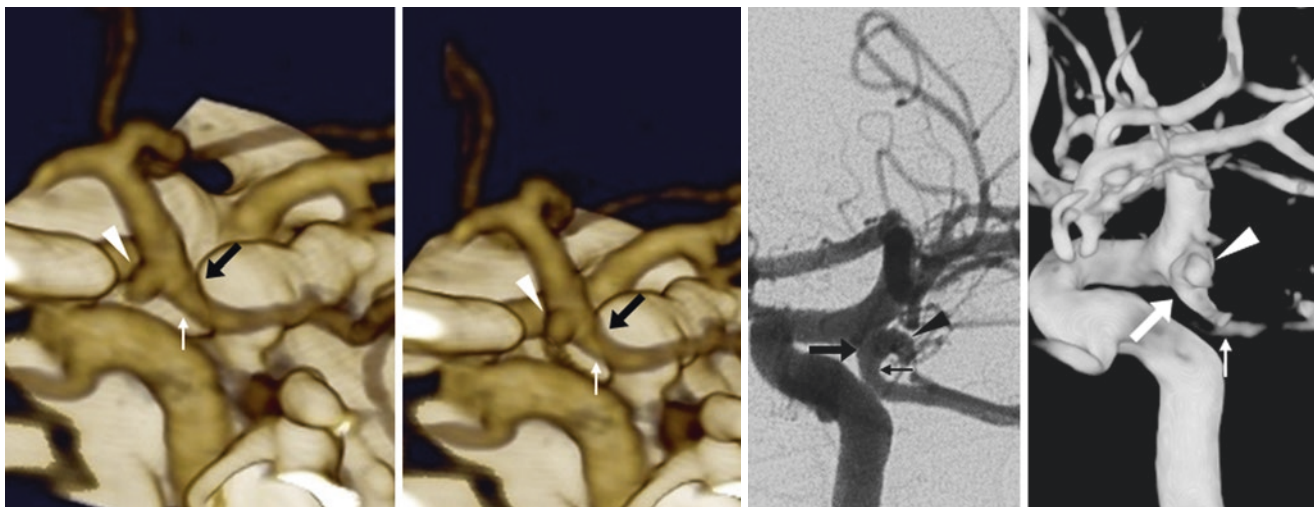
Comparison case of both infundibulum and aneurysm: 23-year-old man with a 2.5-mm PcoA-origin infundibulum (*large arrows*) in a patient with a “fetal PCA” as seen on 3D VR lateral views from a CTA (*left two images*), DSA (*middle right*), and 3DDSA (*far*
